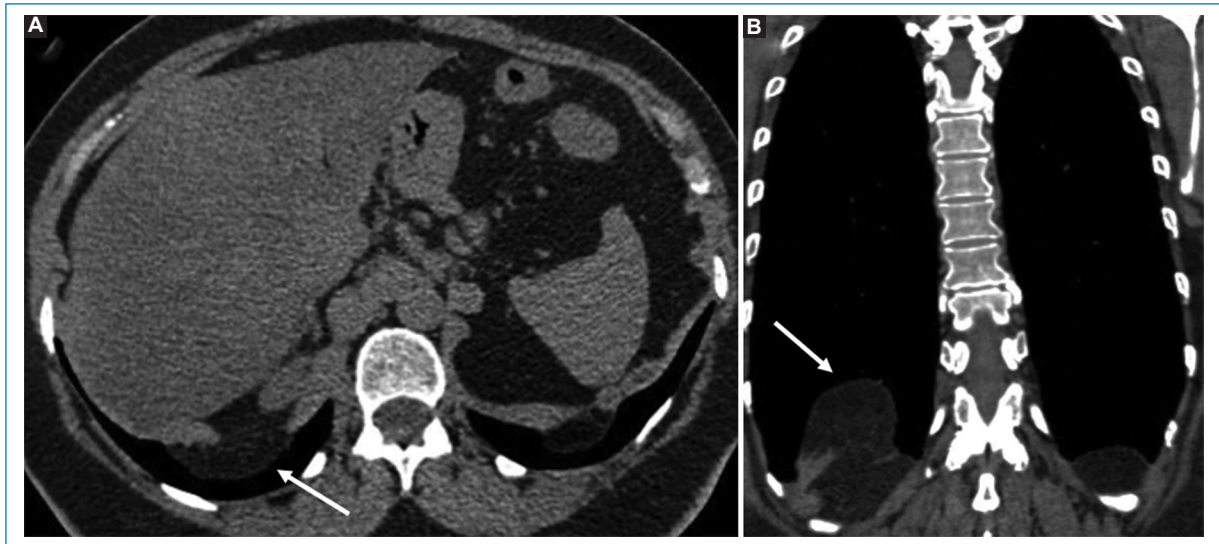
Posterior diaphragmatic defect. Selected images of axial non-contrast multidetector computed tomography of the chest (A) and coronal reconstruction (B), showing a right posterior discontinuity of the diaphragm with ascent of abdominal adipose tissue (white arrows).
